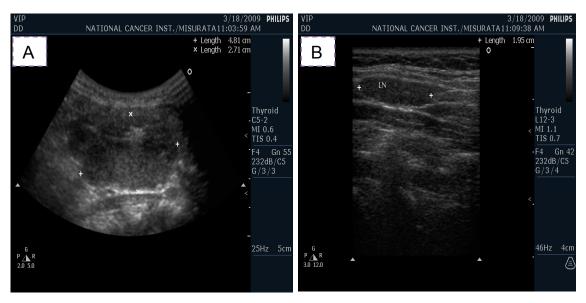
Conventional ultrasound patterns. A: Absence of peripheral halo in thyroid papillary carcinoma (longitudinal section). With hetroechogenicity in papillary thyroid carcinoma (longitudinal section). B: regional LNs, with hetroechogenicity absence of peripheral halo and hypoechogenicity are also present in papillary thyroid carcinoma (longitudinal section)
